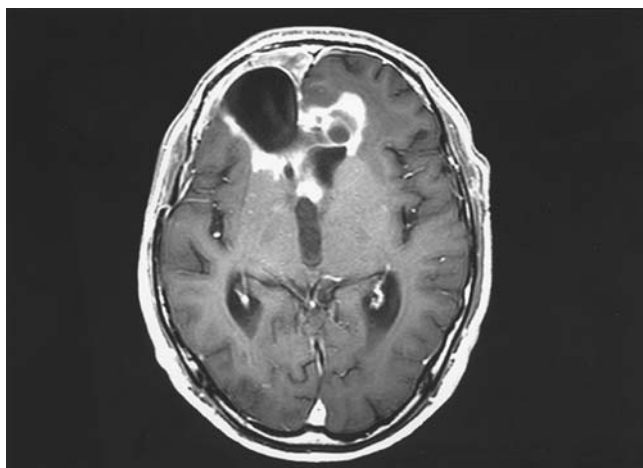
Follow-up of MR images before and after metronomic temozolomide (TMZ) treatment in a 36-year male patient with glioblastoma (case 8). The left MR image shows tumor recurrence in spite of conventional TMZ chemotherapy with PCV administration. The right demonstrates decrease of size in enhanced tumor portion at 2 months after initiation of metronomic treatment (dose 40 mg/m²/day).
